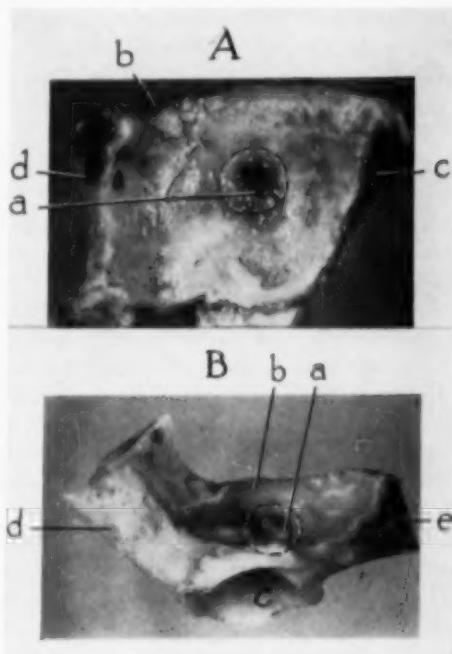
(Reese). Resection of the bony lacrimal-gland fossa for bone invasion by a benign mixed tumor of the lacrimal gland. This was not apparent by X-ray examination or palpation but through direct inspection.
